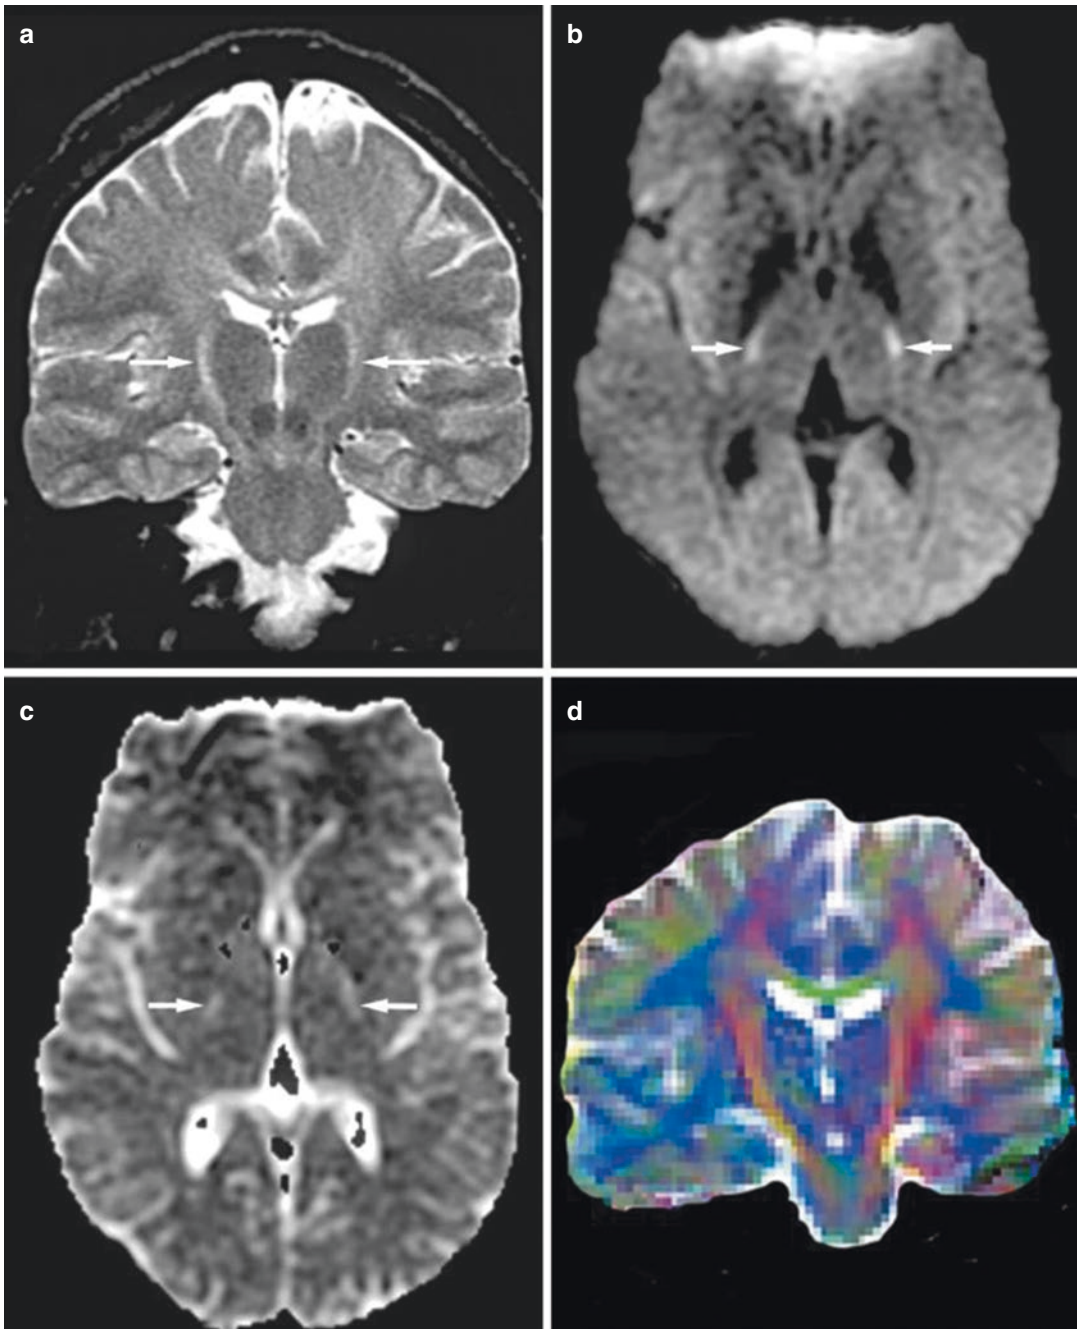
Amyotrophic lateral sclerosis in a 27-year-old man with progressive weakness and dysphagia. (a) Coronal spin-echo T2-weighted image shows bilateral symmetrical hyperintensity along the corticospinal tract (arrows), extending into the white matter of the motor area. (b) DW image shows mild hyperintensity in bilateral
